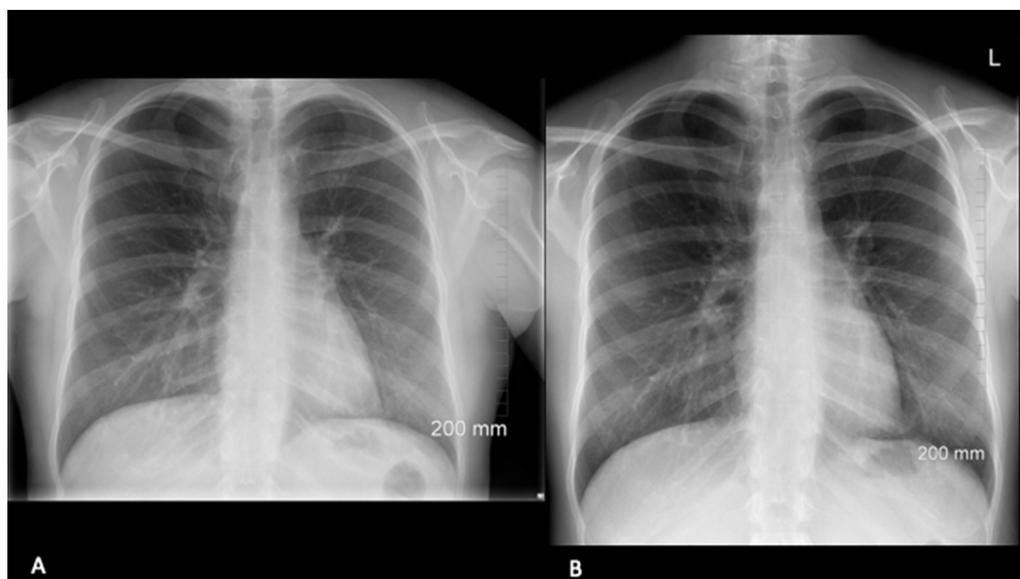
Sequential CXRs of the 26 year-old female taken 4 years apart. (a) The most recent CXR is composed of 2987 horizontal Dels. (b) The prior CXR is composed of 2472 horizontal Dels. Objects in the prior radiograph are displayed larger with a relative image magnification of $515/2472$ or 21%.
